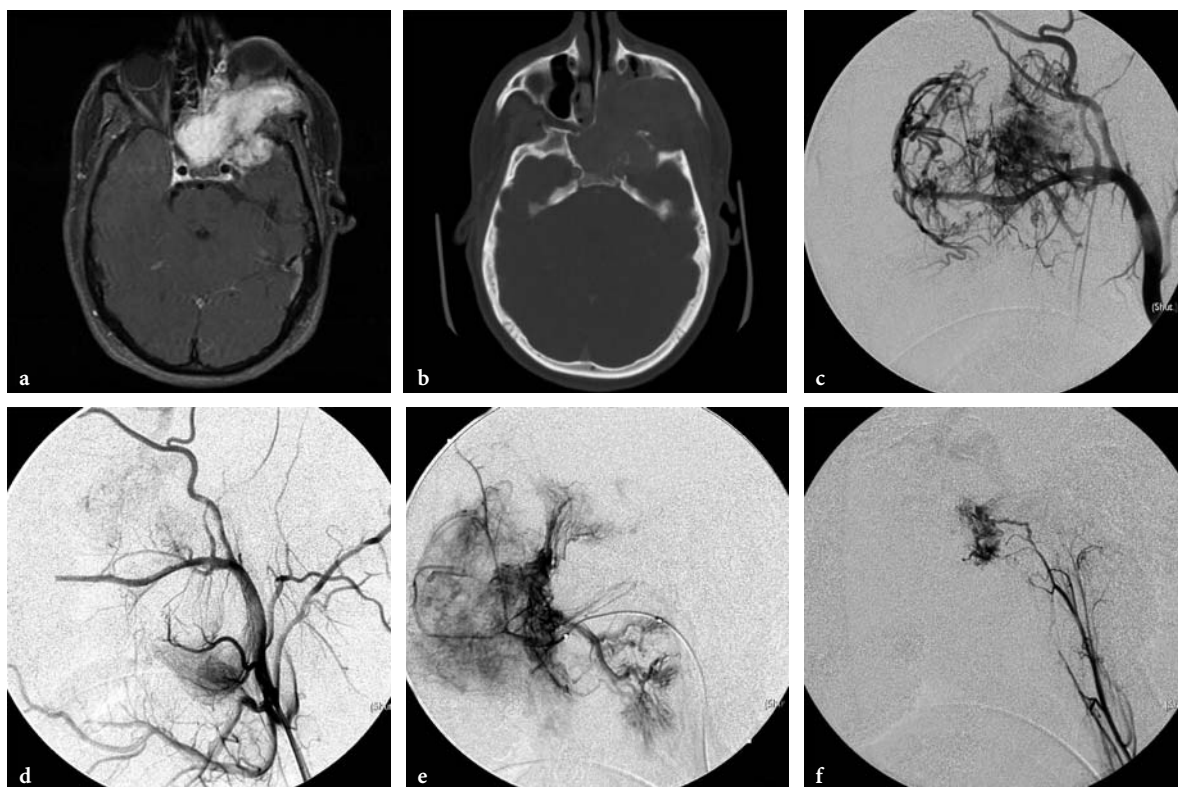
JAF: An 18-year-old male presenting with epistaxis. The MRI and the CT scan shows orbital and intracranial (left temporal fossa) extension of tumor with significant bony erosion (a,b). Angiogram shows tumoral blush arising from the internal maxillary artery, the facial artery and the ascending pharyngeal artery (c-f). Preoperative embolization with particles was performed after selective catheterization of the feeding arteries. Courtesy of Dr. K. terBrugge
